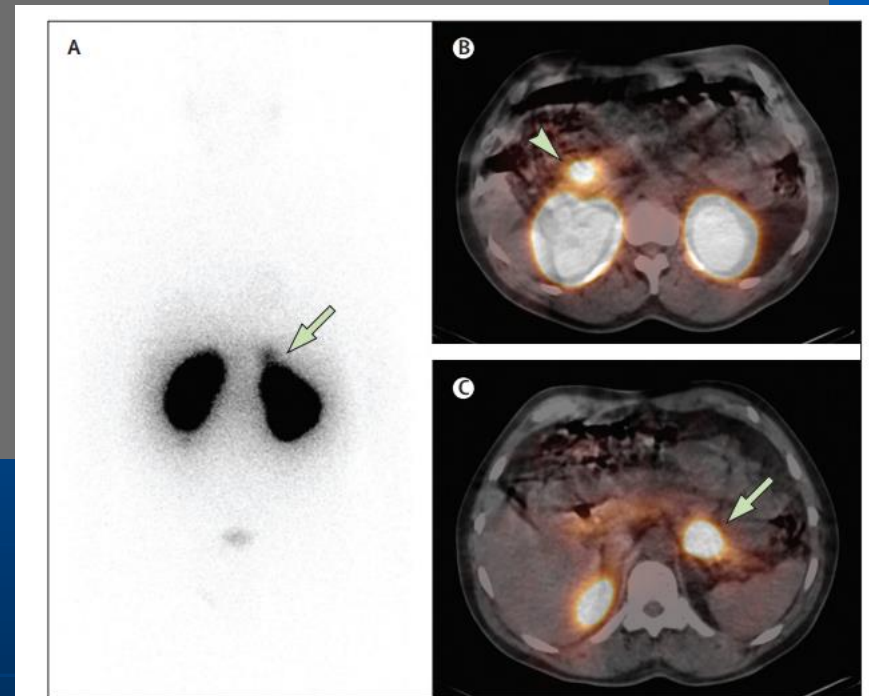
Whole-body planar image (A) and SPECT/CT images (B and C) from patient 29, 4 h after injection of 108 MBq ^{111}In -DTPA-exendin-4.
